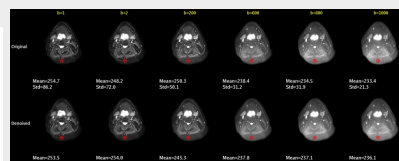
Comparison of DWIs before and after DWI-Agent's denoising tool processing.
